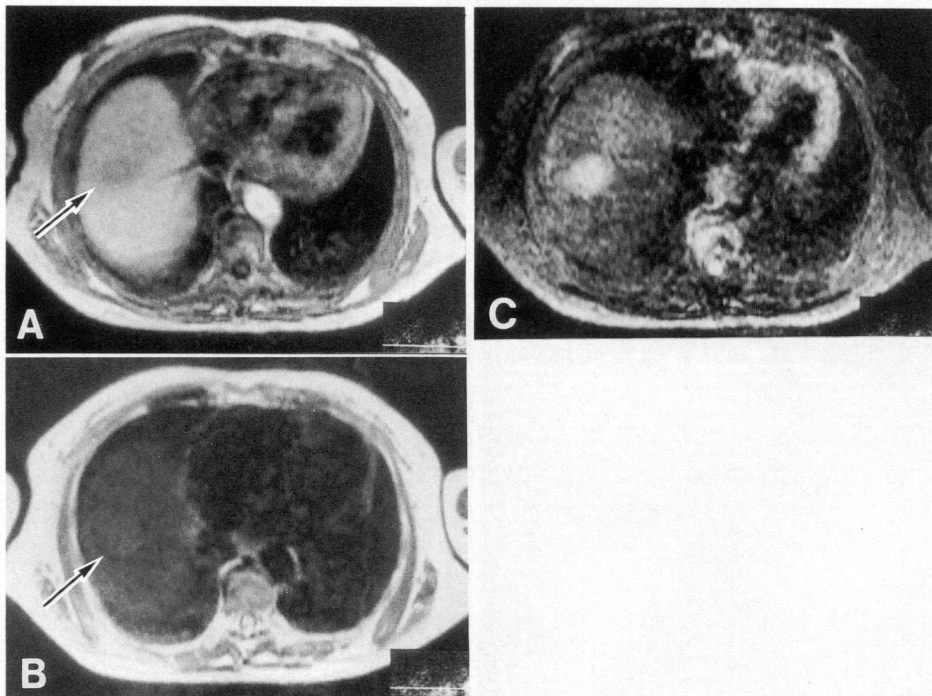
MR imaging of primary hepatocellular carcinoma.
